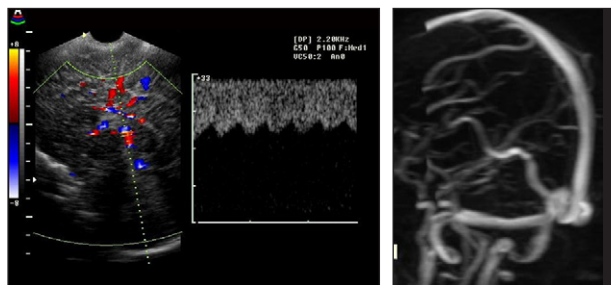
Echo color Doppler.
